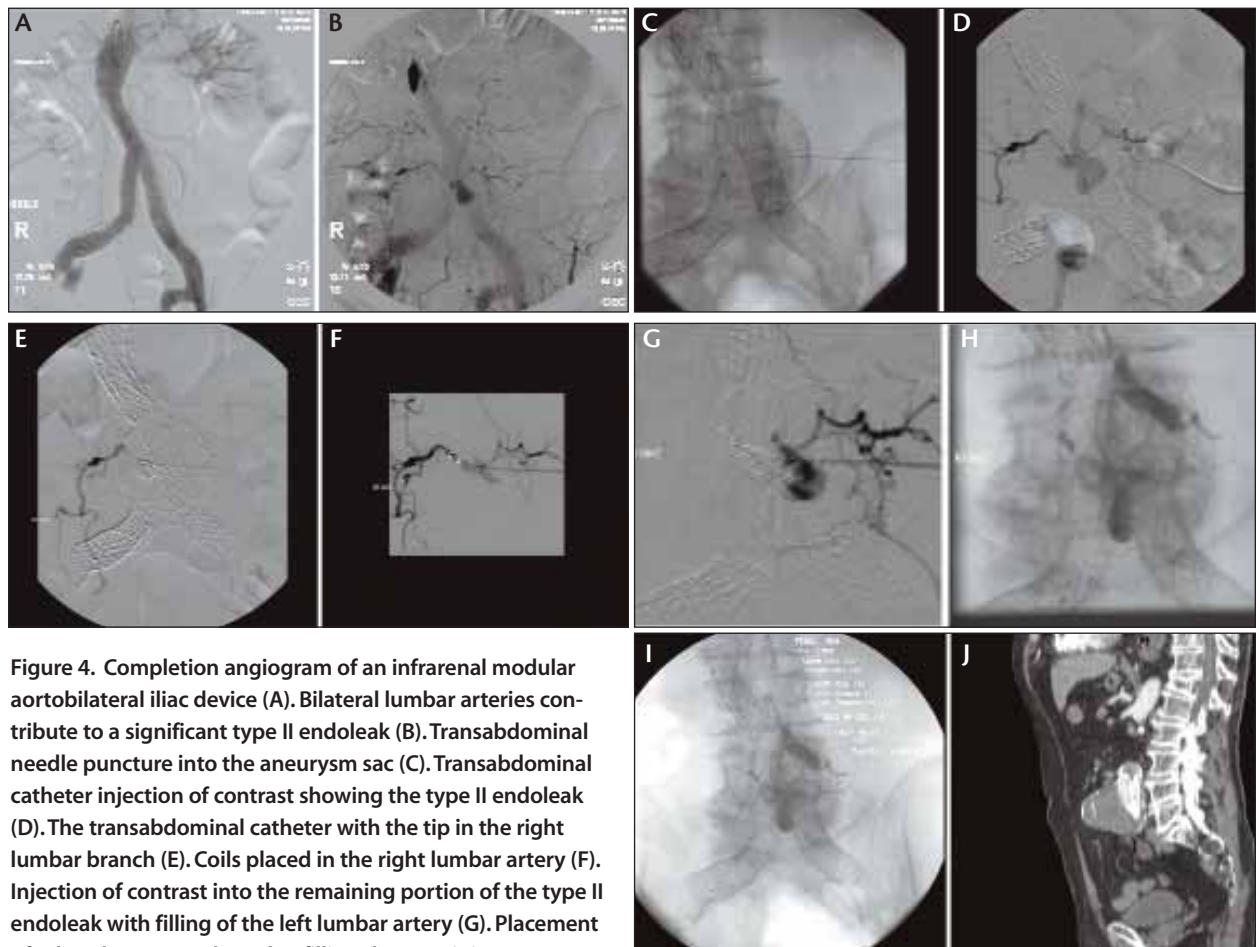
Completion angiogram of an infrarenal modular aortobilateral iliac device (A). Bilateral lumbar arteries contribute to a significant type II endoleak (B). Transabdominal needle puncture into the aneurysm sac (C). Transabdominal catheter injection of contrast showing the type II endoleak (D). The transabdominal catheter with the tip in the right lumbar branch (E). Coils placed in the right lumbar artery (F). Injection of contrast into the remaining portion of the type II endoleak with filling of the left lumbar artery (G). Placement of n-butyl cyanoacrylate glue filling the remaining type II endoleak cavities and all other branches supplying the endoleak (H). Complete obliteration of the type II endoleak nidus with coils and n-butyl cyanoacrylate glue (I). A sagittal reconstructed CT scan shows no residual endoleak (J).
